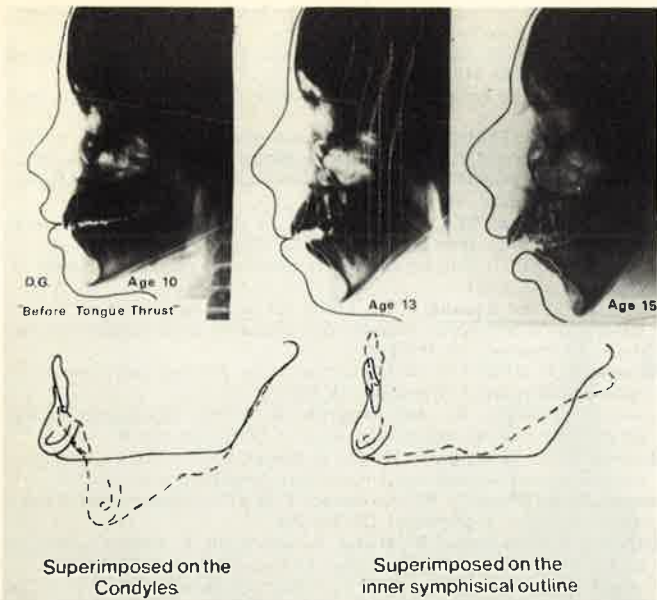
Three lateral radiographs taken at the ages of 10, 13 and 15, of a girl who developed a flacid swallow. Inset is a tracing of the mandible taken from the first and last radiographs (age 10·5 continuous line, age 14·11 intermittent line).
